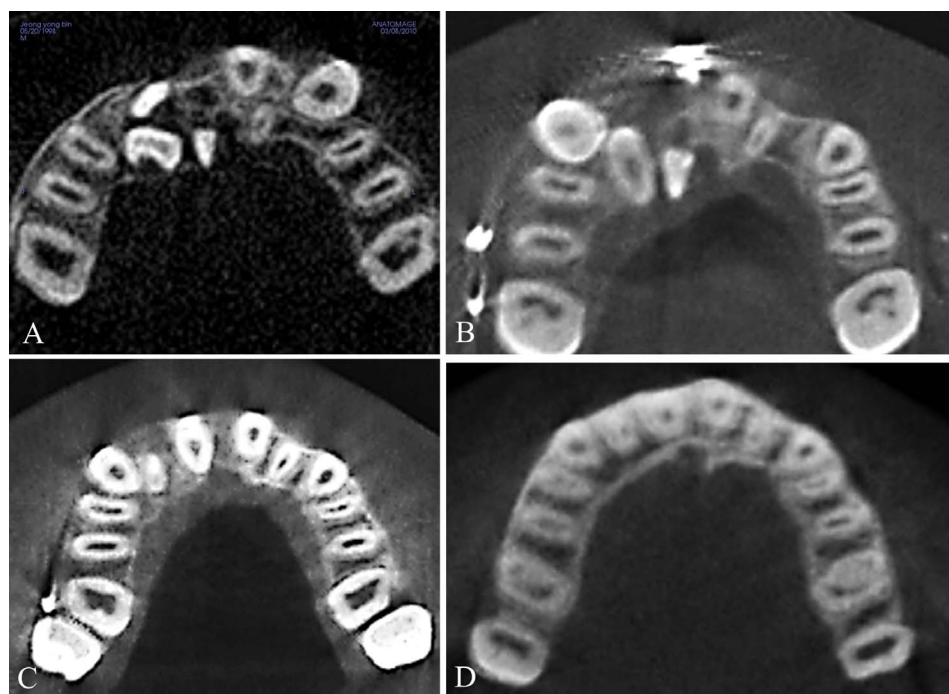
Axial images of CBCT: (A) pretreatment; (B) 3-month treatment period; (C) 31-month treatment progress; and (D) 30 months posttreatment.
